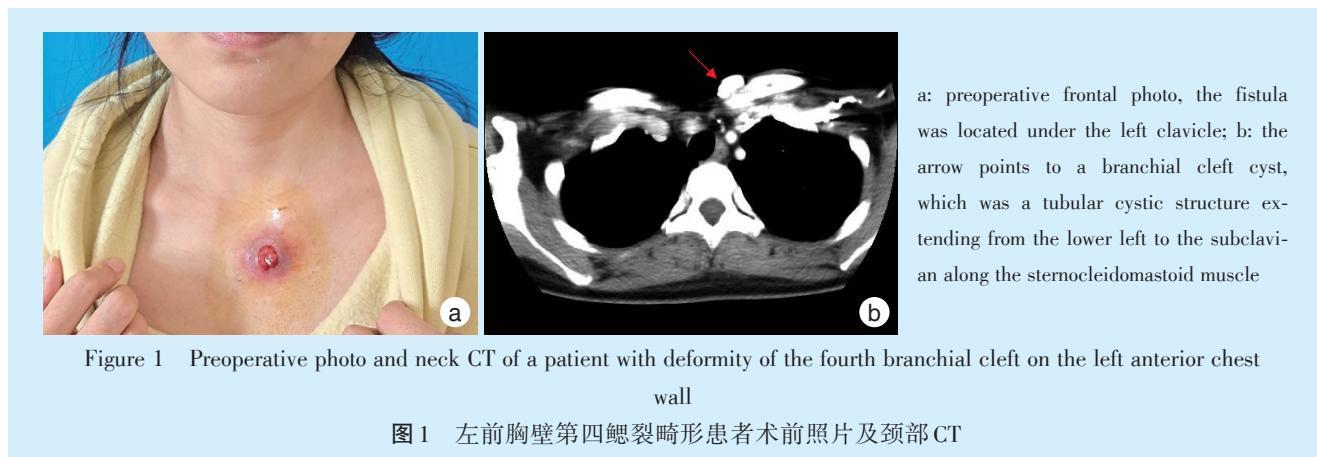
Preoperative photo and neck CT of a patient with deformity of the fourth branchial cleft on the left anterior chest wall
